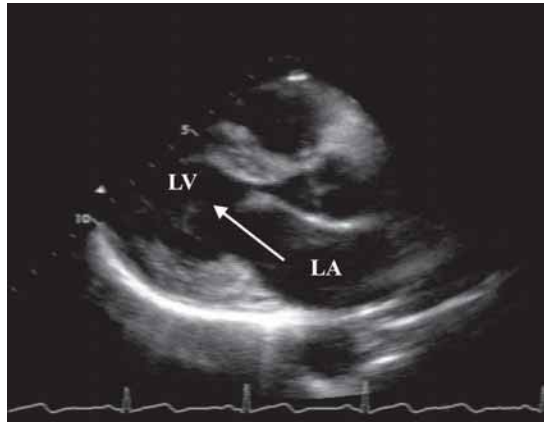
Stop frame of a two-dimensional echocardiogram taken from a normal subject in the parasternal long axis at the end of the rapid filling phase of diastole when the moving column of blood (arrow) entering the left ventricle (LV) from the left atrium (LA) is suddenly decelerated because of the fact that the rapid expansion suddenly changes to a period of slower expansion. Factors that make the transition more abrupt tend to produce an S3 (*see* the text).
